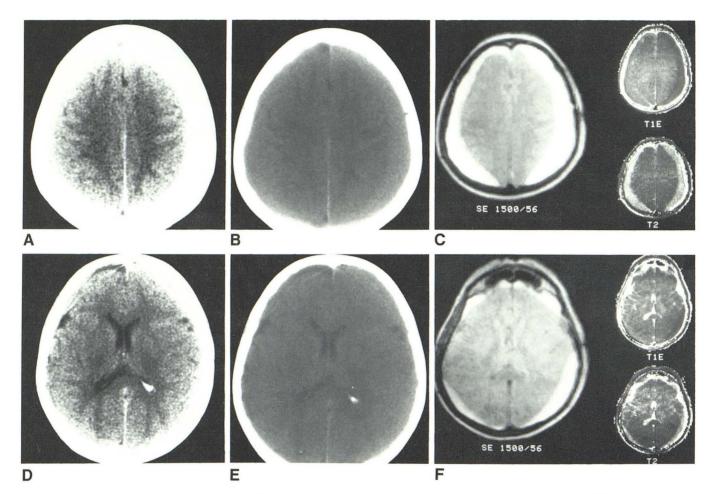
Transaxial sections above lateral ventricles (A–C) and through basal ganglia (D–F). A and D, CT scans with window levels of 40 H and widths of 80 H. B and E, CT scans with window levels of 80 H and widths of 300 H. C and F, NMR SE 1500/56, T1 estimate (T1E), and T2 images. On T1E and T2 images, high intensity corresponds to longer T1 and T2 values.
